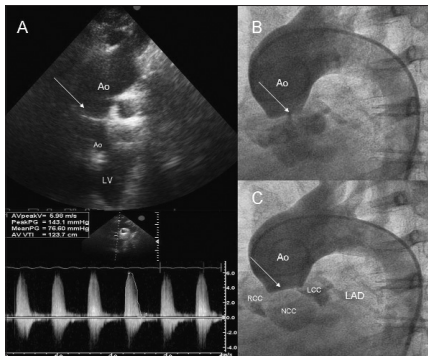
Transthoracic echocardiogram (A) and aortogram (B, C) showing a discrete fibrous membrane (arrows) above sinuses of Valsalva
